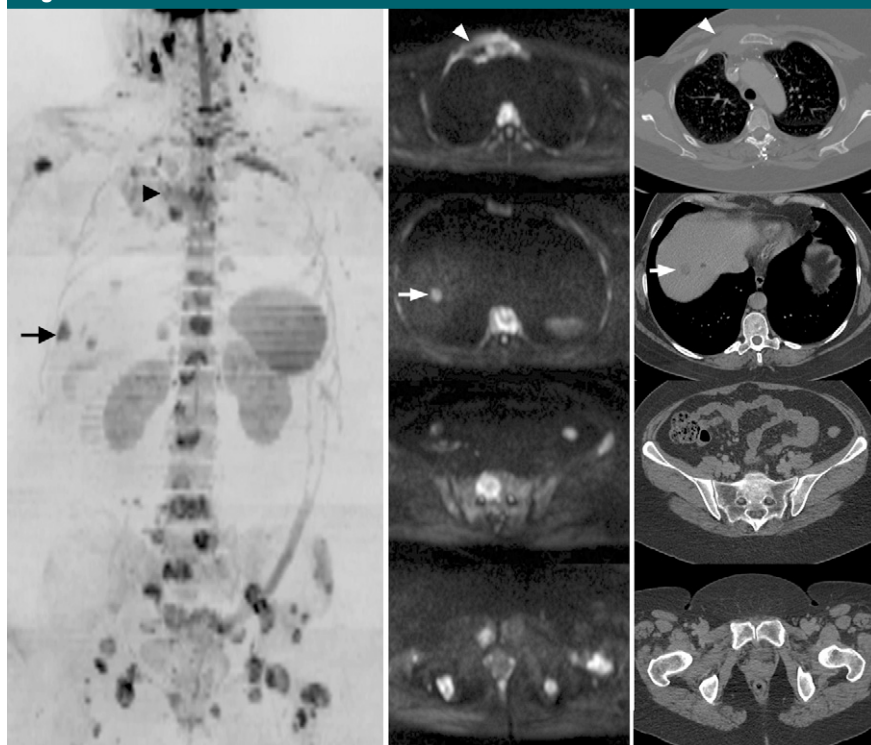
Whole-body DW imaging versus CT for detection of bone metastases in 51-year-old woman with metastatic breast cancer and history of right mastectomy and axillary nodal dissection. Extensive bone metastases are well depicted on whole-body DW (left; inverted gray scale) and source DW (middle; original gray scale) images. Bone metastases are poorly depicted on corresponding unenhanced CT scans (right) obtained 2 weeks later (bone and soft-tissue windows at various levels). Arrowhead = parasternal recurrence, arrow = liver metastasis.
